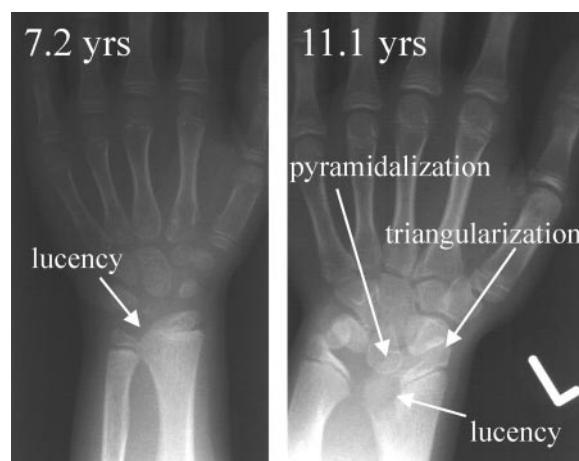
Radiography of patient 1 (left) and patient 2 (right) with *SHOX* haploinsufficiency, showing the main characteristics of mild LWD.
